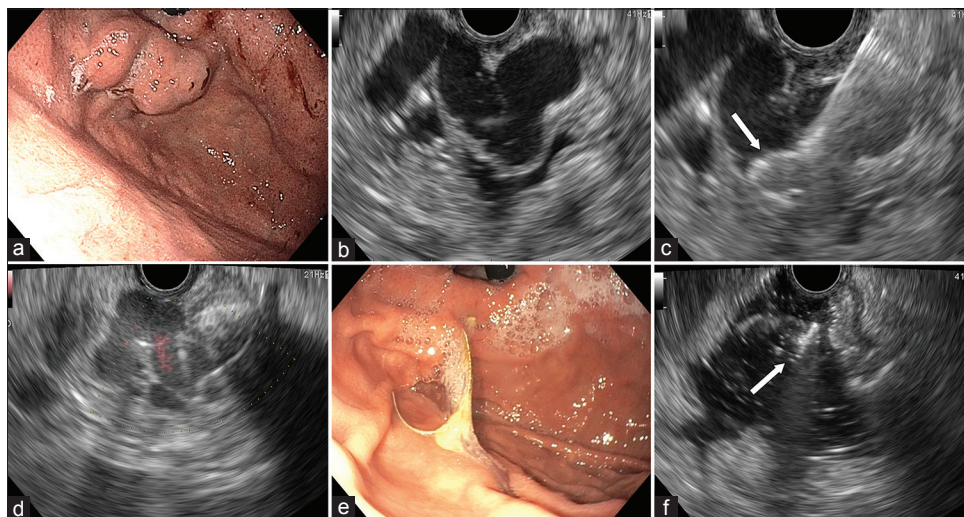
(a) Type I isolated gastric variceal conglomerate in a patient with a history of bleeding. (b) Sonographic image of the 2.5 cm variceal conglomerate. (c) Deployment of a coil through a 19-gauge needle (arrow pointing to coil). (d) Coil and glue complex (creating acoustic shadow) with nearly no flow confirmed by Doppler. (e) Varix obliterated with coil extruding. (f) No varix seen on sonography with the coil visible in the gastric lumen (arrow)
